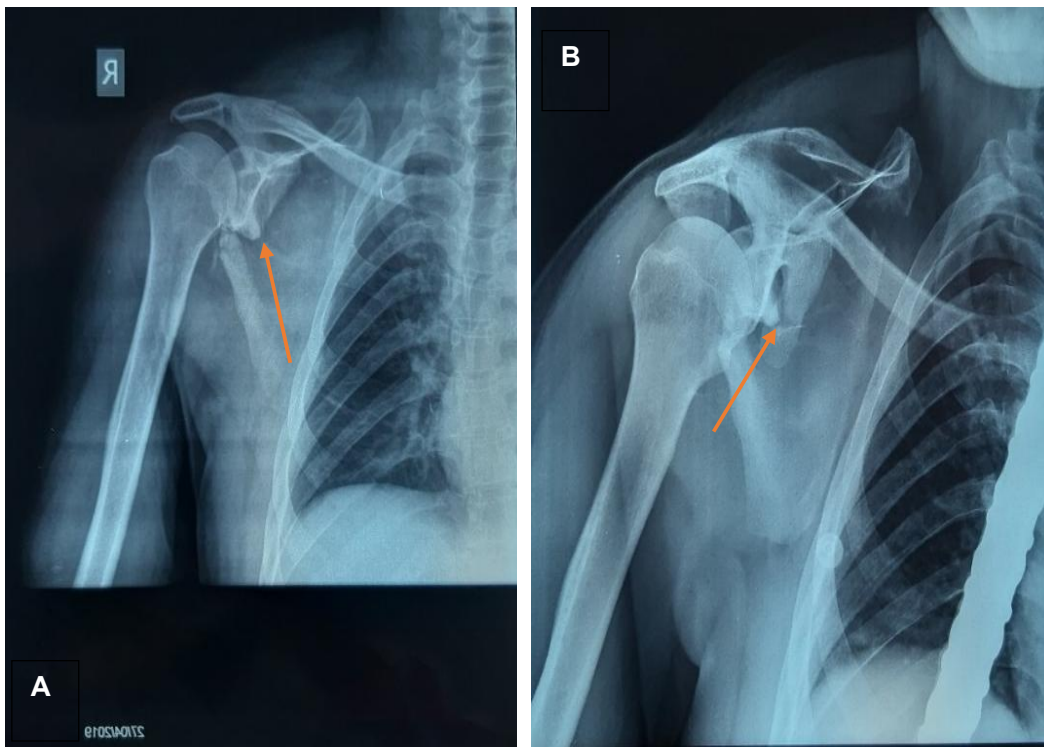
Frontal x-ray, A. The arrow at the right shoulder showed a comminutive fracture of the body of the scapula associated with a fracture of the scapula spine, B. The arrow at the left shoulder showed the comminutive fracture of the body of the scapula
